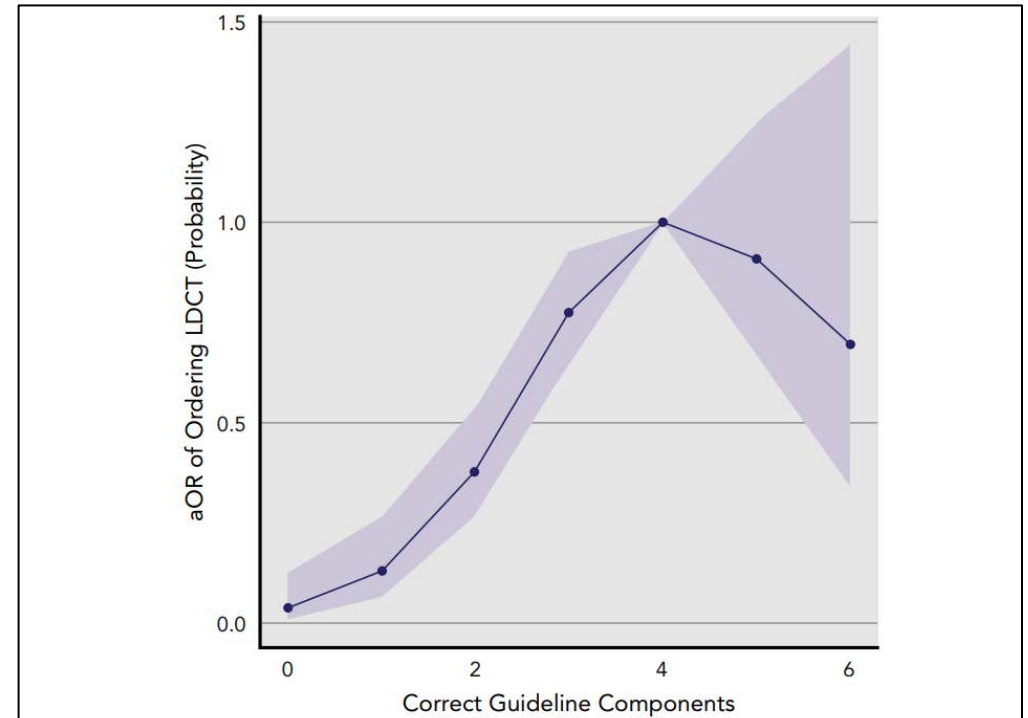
LDCT screening by knowledge as a continuous variable. Abbreviations: aOR, odds ratio; LDCT, low-dose CT.
